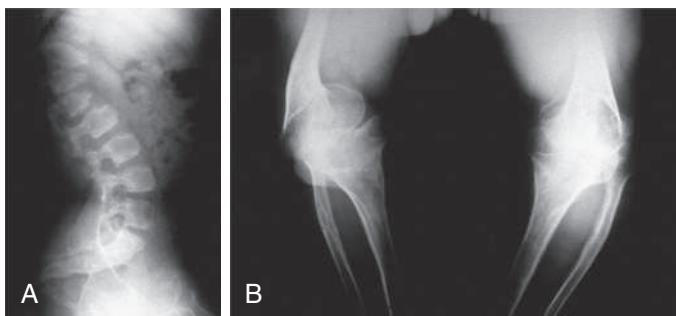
A, Lateral thoracolumbar spine radiograph of a patient with pseudoachondroplasia showing central protrusion (tonguing) of the anterior aspect of upper lumbar and lower thoracic vertebrae. Note reduced vertebral body heights (platyspondyly) and secondary lordosis. B, Lower-extremity radiograph of a patient with pseudoachondroplasia showing large metaphyses, poorly formed epiphyses, and marked bowing of the long bones.
